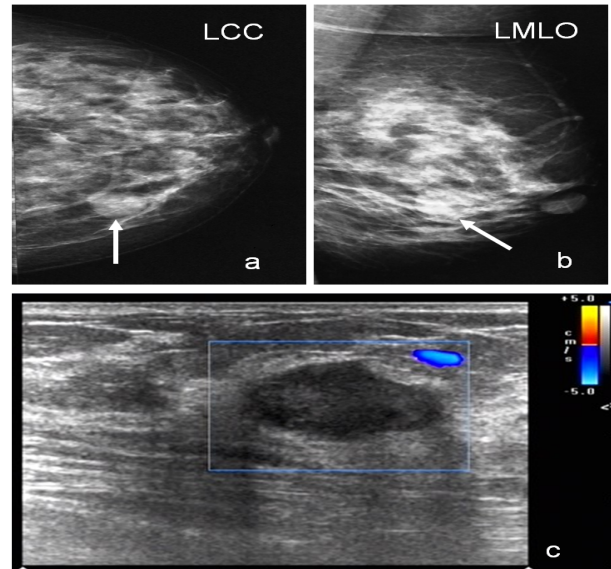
a) and b) Mammography displayed an isodensity TNBC Mass with Circumscribed Margin in the Inner Upper Quadrant of the left Breast(arrows). c) In Ultrasound, the Mass had a Low Echoic Area with Regular Shape and Circumscribed Margin, Avascular Flow Imaging and no Change Posterior Echoes
